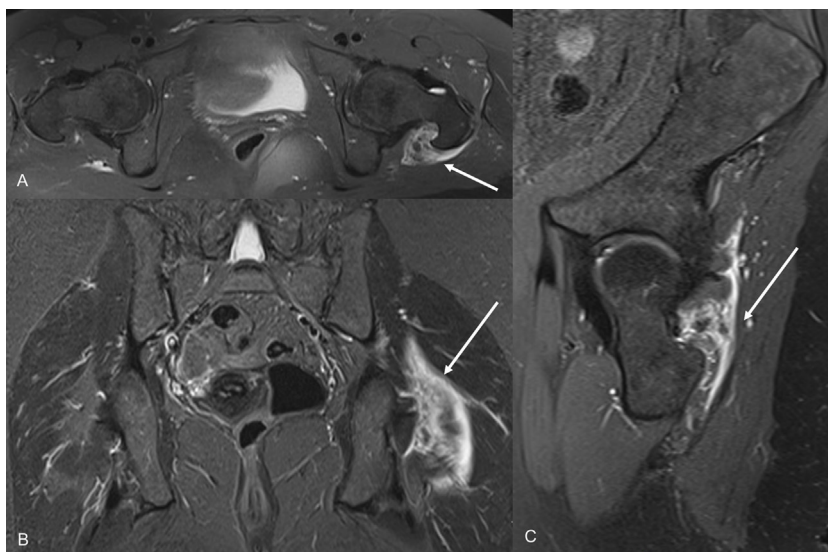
Axial (A) and sagittal (C) PD fluid sensitive and coronal STIR (B) MRI sequences. There is extensive fatty and peritendinous edema surrounding the posterior facet of the left greater trochanter with fluid distention of the greater trochanteric bursa (white arrows).
